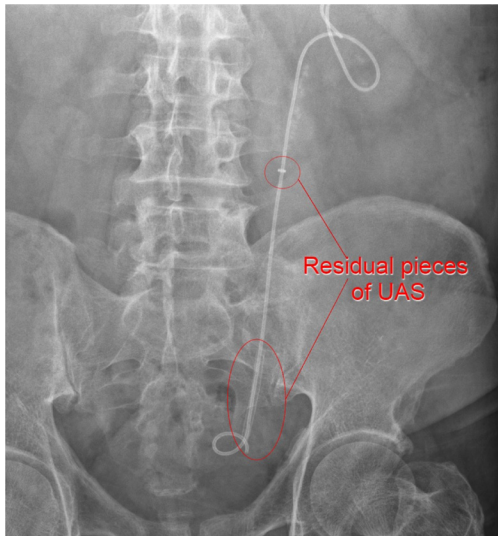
Postoperative kidney ureters bladder X-ray (KUB)
